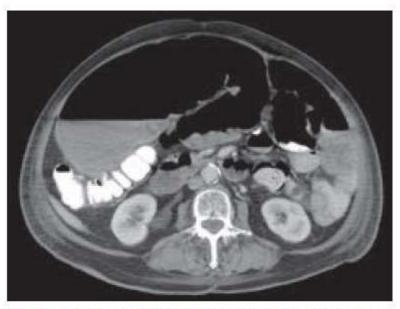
Axial CT of the abdomen post-oral contrast showing dilated loops of fluid and air-filled large bowel (contrast medium is in the small bowel). The cause or level of obstruction is not clear.
